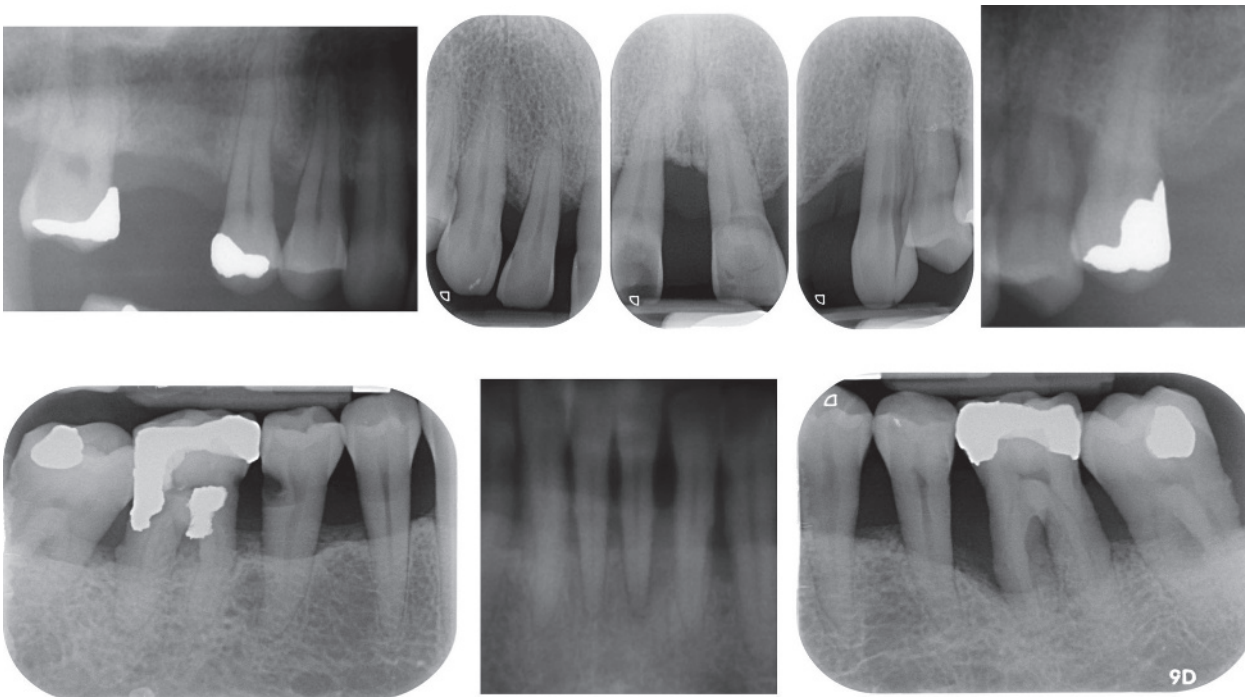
Preoperative full-mouth periapical radiographs showing the extent and severity of periodontal bone loss and presence of multiple periapical radiolucencies.
